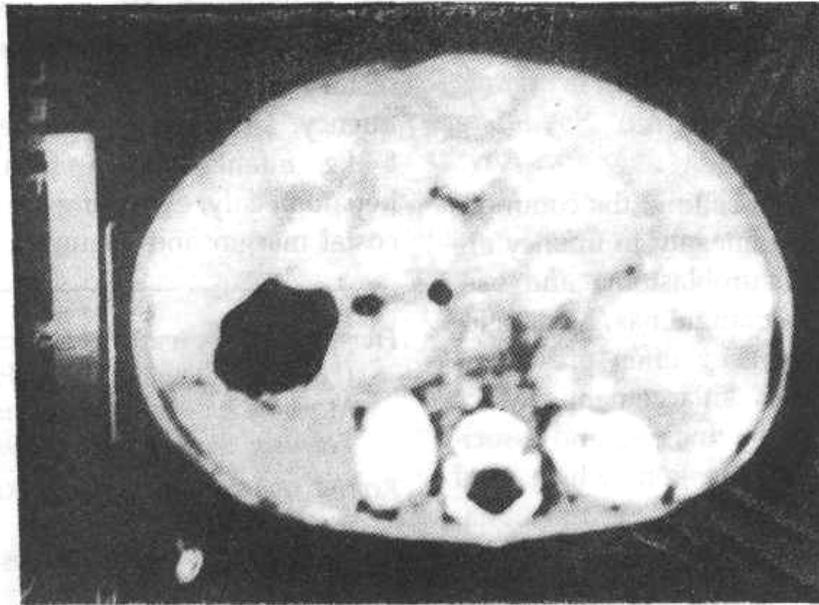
Pre-treatment CT scan of abdomen.
